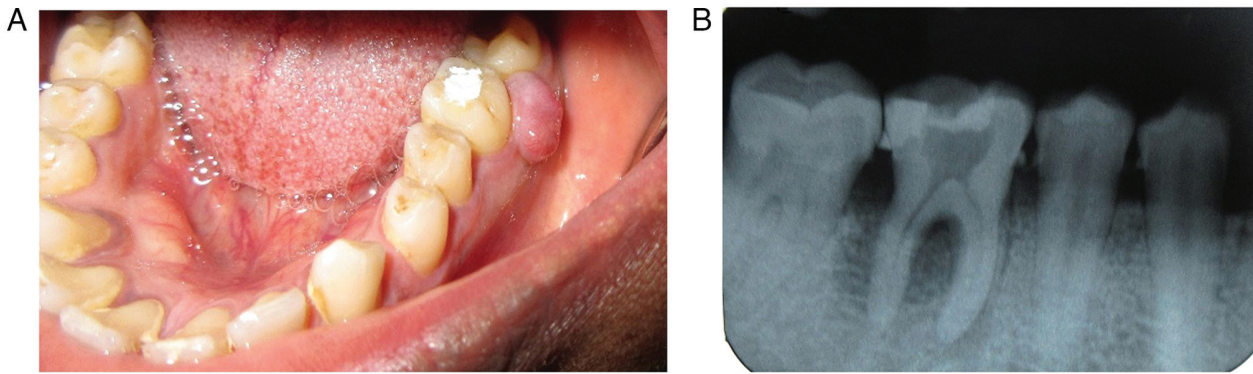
Pre-operative clinical and radiographic assessment of tooth no. 36. (A) Pre-operative clinical image with respect to tooth no. 36. (B) Pre-operative intraoral periapical radiograph with respect to tooth no. 36.
